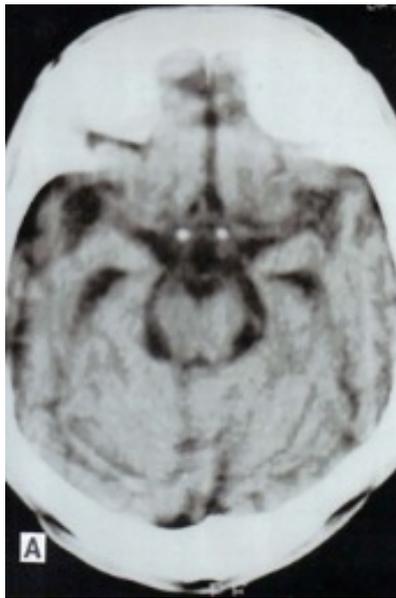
CT scan without contrast showing atherosclerosis at the circle of Willis and its terminal branches, in a 35 year old man with familial HD [8].
